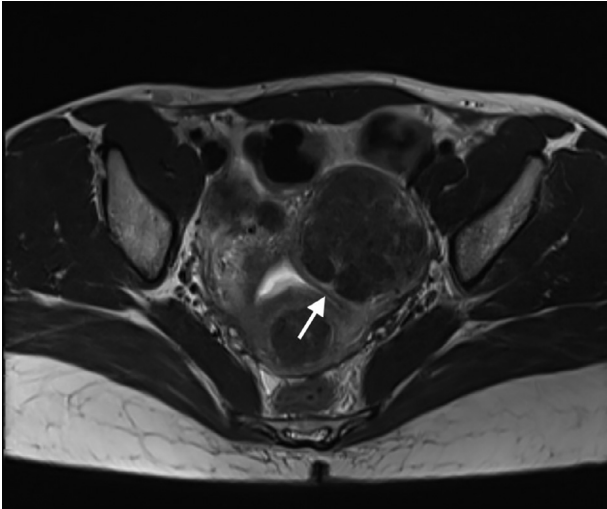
Pre-embolization state (2017) T2-weighted MRI axial view shows multiple myoma and pressure on endometrium (arrow).
